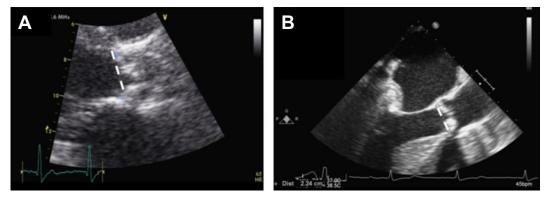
Methodology for the assessment of the AoA using TTE and TEE. TTE (Panel A): the AoA diameter is measured in a parasternal long-axis view on the left ventricular outflow tract at the point of insertion of the right and non-coronary aortic leaflet in mid-systole (dotted line). TEE (Panel B): the AoA diameter is measured on the mid-esophageal 120° to 140° long-axis view on the left ventricular outflow tract at the point of insertion of the right and non-coronary aortic leaflet in mid-systole (dotted line). AoA: aortic annulus; TEE: transesophageal echocardiography; TTE: transthoracic echocardiography.
